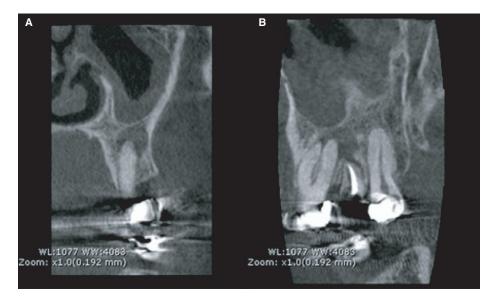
Initial CBCT showing radiolucency associated with 26 and 27 roots. Date of exposure: 27 July 2013. (A) coronal view; (B) sagittal view.
